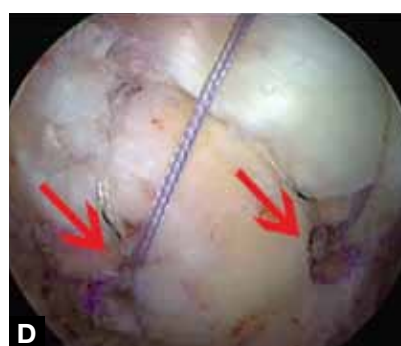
(A) Axial and (B) coronal magnetic resonance imaging demonstrates shoulder dislocation.
